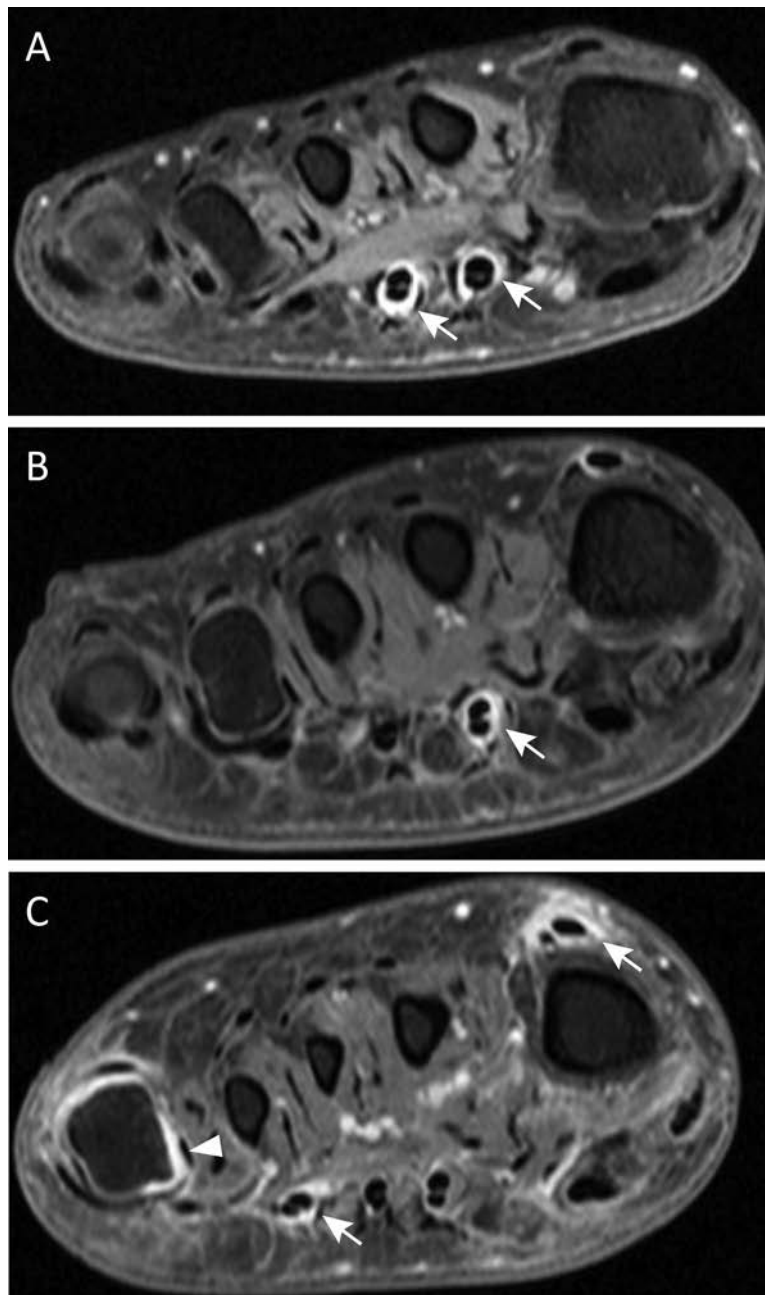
Examples of magnetic resonance imaging–detected tenosynovitis (arrows) in the coronal plane. A, Tenosynovitis of the common flexor digitorum at the 2nd and 3rd metatarsophalangeal (MTP) joint; B, Tenosynovitis of the common flexor digitorum at the 2nd MTP joint; and C, Tenosynovitis of the extensor hallucis longus and common flexor digitorum of the 4th MTP joint, with synovitis of MTP-5 (arrowhead).
